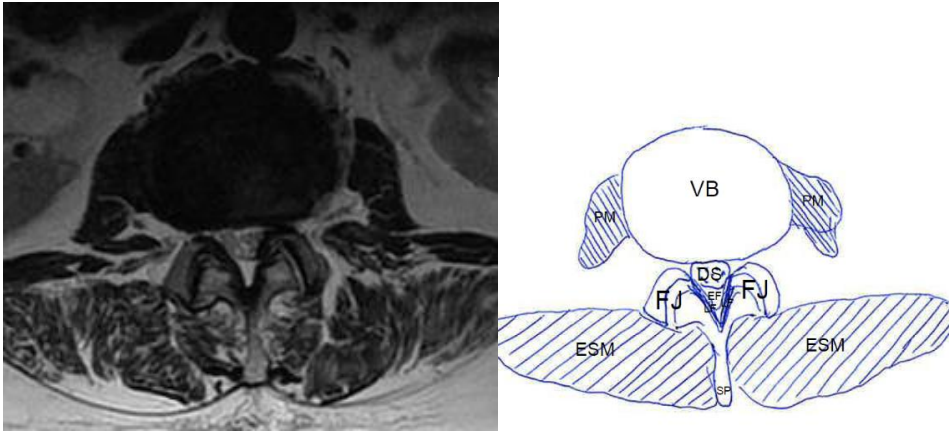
Transverse view (axial) of the lumbar spine in MRI in an asymptomatic segment; the cross-sectional area for the dural sac (DS) is slightly reduced but still sufficient. VB = Vertebral body, D = Intervertebral disc, DS = Dural sac, SP = Spinous process, LF = Ligamentum flavum, F = Fascia, SF= Subcutaneous fat, FJ = Facet joint, PM = Psoas muscle, ESM = Erector spinae muscle.
